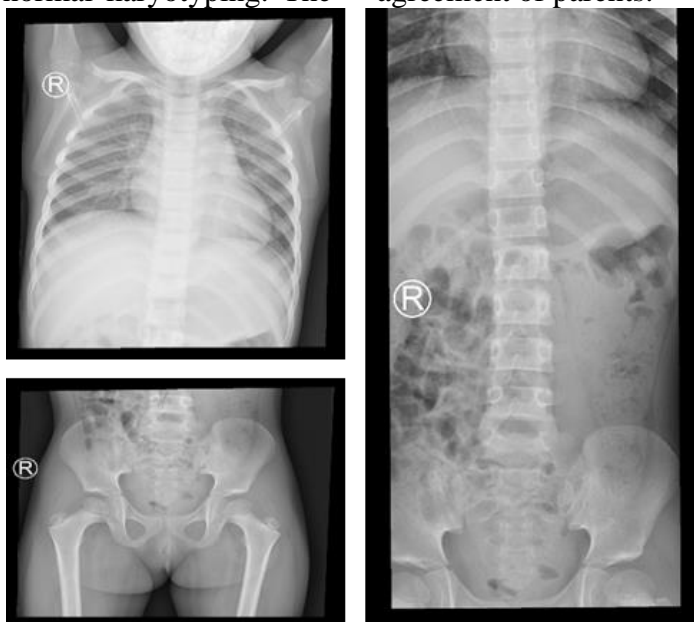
The X-ray images showed a shortening of long bones, short and broad femoral neck, and squared and shortened ilia in the patient.
